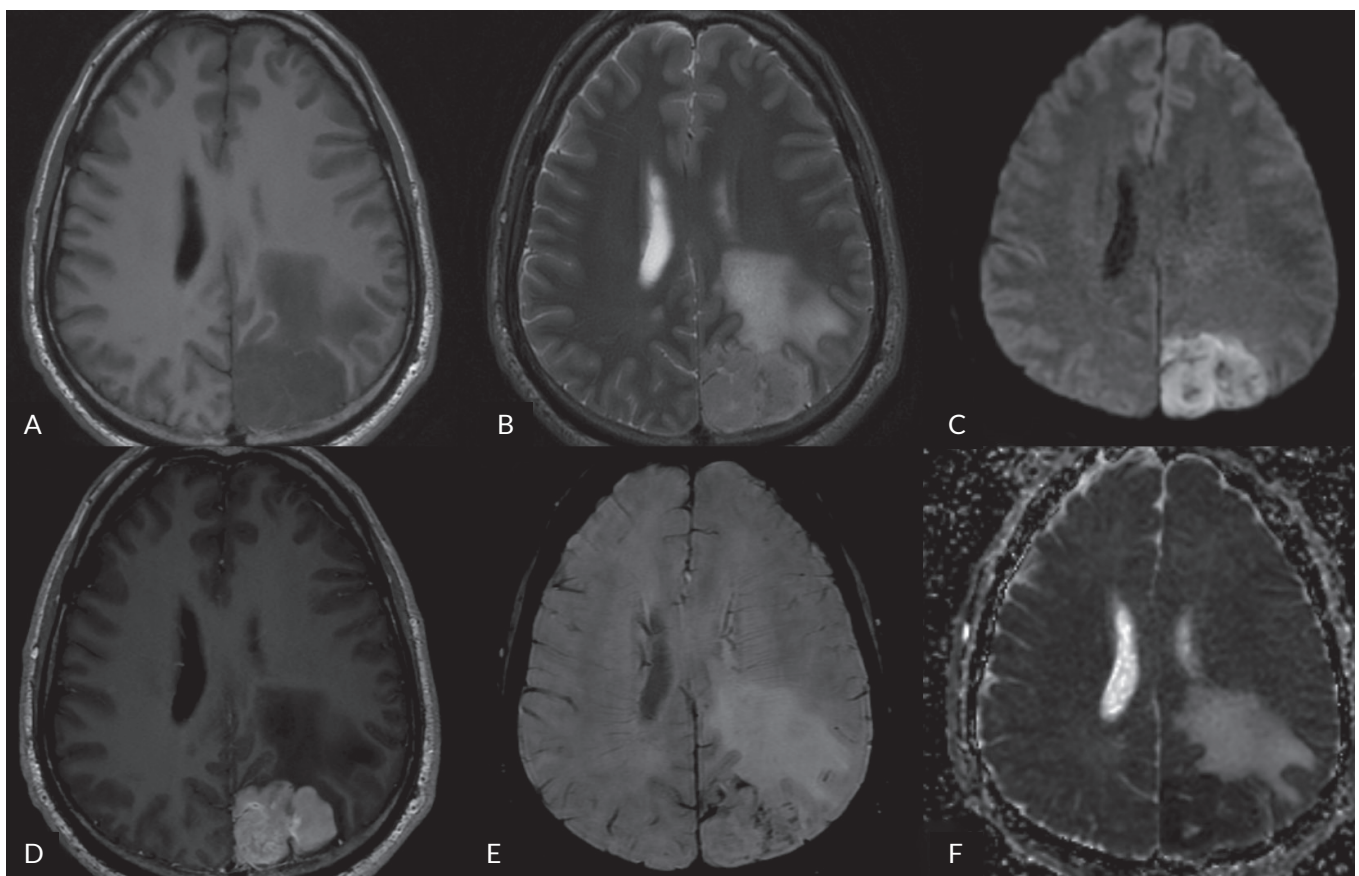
Selected MRI scans of the head, obtained during the patient's initial hospital stay, show two adjacent lymphomas in the left parieto-occipital region. A. Pre-contrast T1-weighted image. B. T2-weighted image. C. DWI image. D. Post-contrast T1-weighted image. E. SWAN image. F. ADC map
